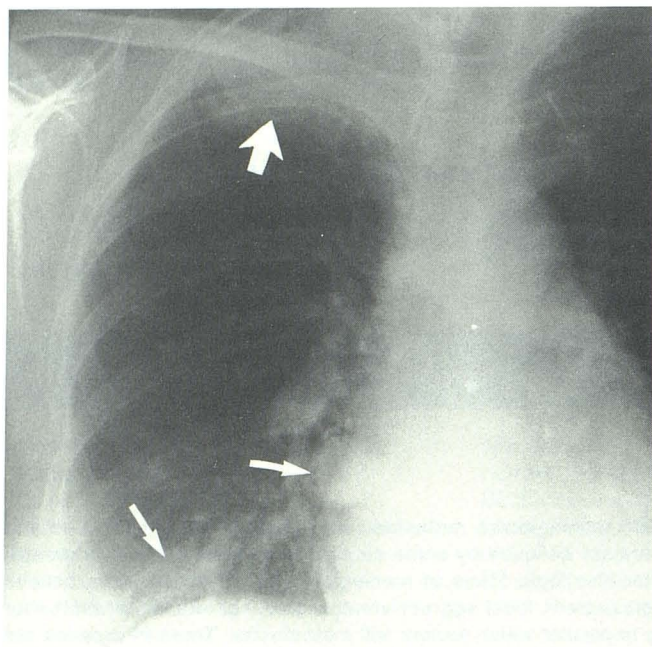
Posteroanterior chest radiograph reveals two metastatic parenchymal nodules (*small arrows*). Third apical mass (*large arrow*) was both parenchymal and pleural with erosion of posterior margin of third right rib.
